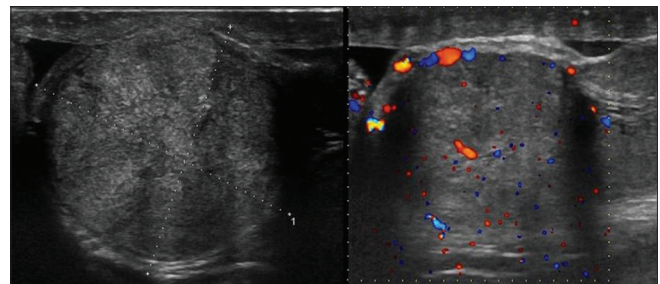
Grayscale US and color Doppler images show a well-defined, round hyperechoic epididymal lesion superior to the upper pole of the left testis (Solid black arrow) showing minimal vascularity on color Doppler
